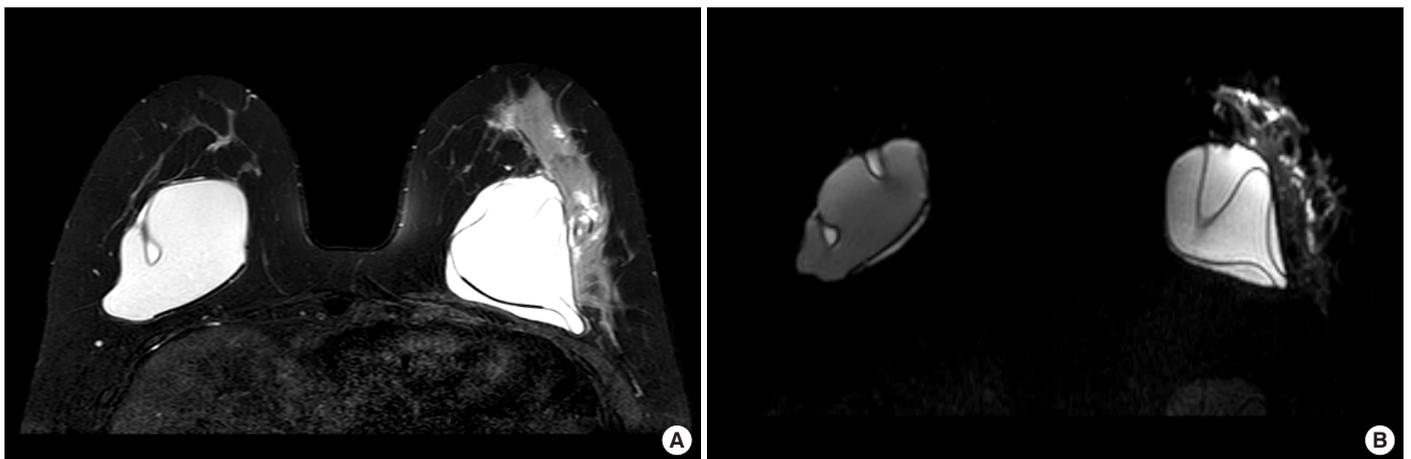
Magnetic resonance image of the patient's breasts. (A) Diffuse wall enhancement is noted on the lateral side of the left breast. (B) Silicone suppression showed that the signal intensity of the inner material was still high, indicating that the implant might be a hydrogel implant.
